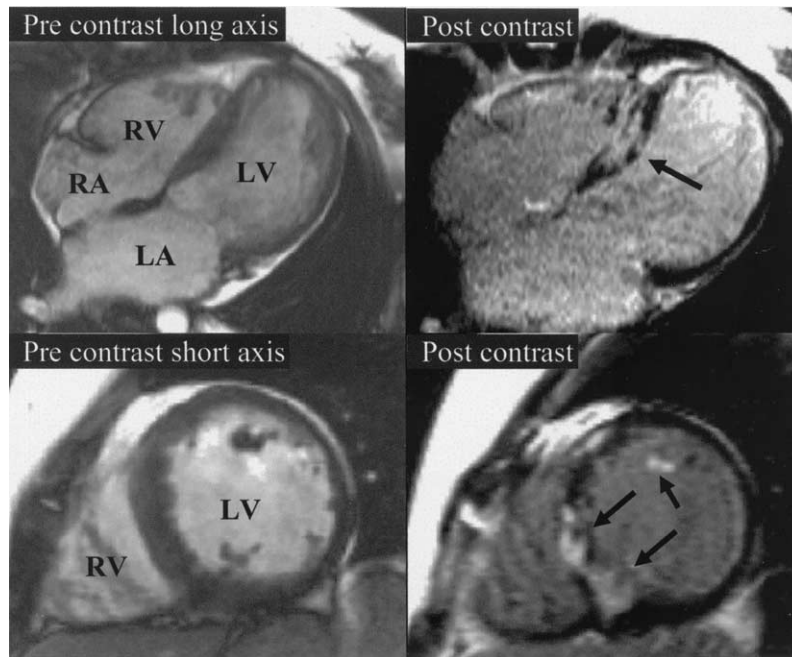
Pre- and post-contrast images demonstrating hyperenhancement. The pre-contrast images are the diastolic frames of fast imaging with steady-state precession cine loops. In the post-contrast images, normal myocardium appears dark. There is a large area of septal hyperenhancement, with additional papillary muscle hyperenhancement and subendocardial hyperenhancement of the lateral wall. The patient is a 33-year-old female with two risk factors for sudden death. Eight years previously, echocardiography demonstrated marked asymmetric septal hypertrophy, but the ventricle is now thinning and dilating and left bundle branch block has developed. The total extent of hyperenhancement was 25% of the left ventricular (LV) mass. LA = left atrium; RA = right atrial; RV = right ventricle.
